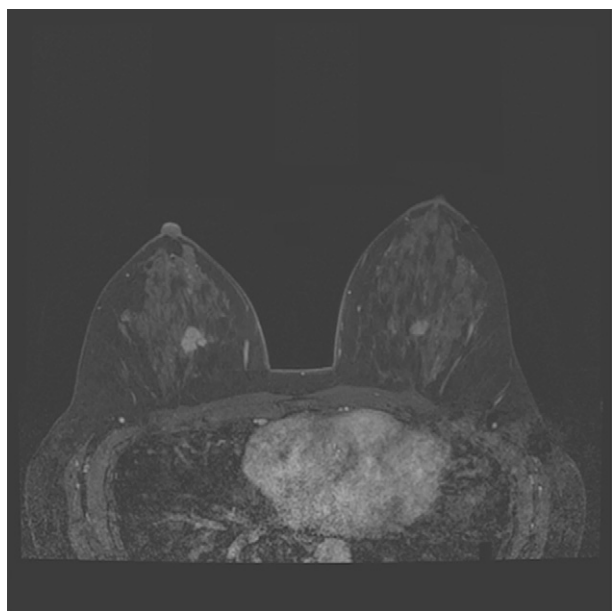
MRI showing bilateral breast cancers.
